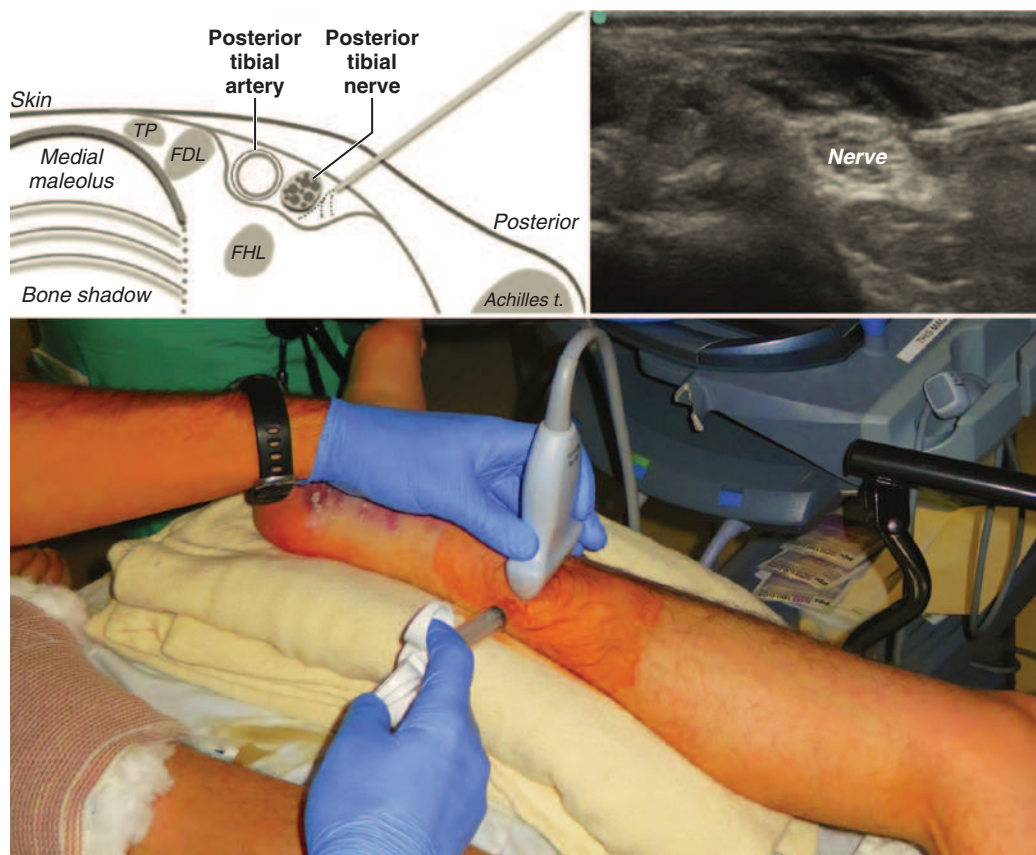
Ultrasound-guided posterior tibial nerve block. The posterior tibial nerve is easily blocked at the medial aspect of the ankle, where the nerve can be found as a hyperechoic, honeycomb structure just adjacent (most often posterior) to the posterior tibial artery. The flexor digitorum longus (FDL), flexor hallucis longus (FHL), and tibialis posterior (TP) tendons are adjacent structures that can have a nerve-like appearance on ultrasound. Tracing the structure in question proximally will clarify its identity; the tibial nerve can be followed proximally in the leg, while tendons quickly arrive at their muscle origins.
